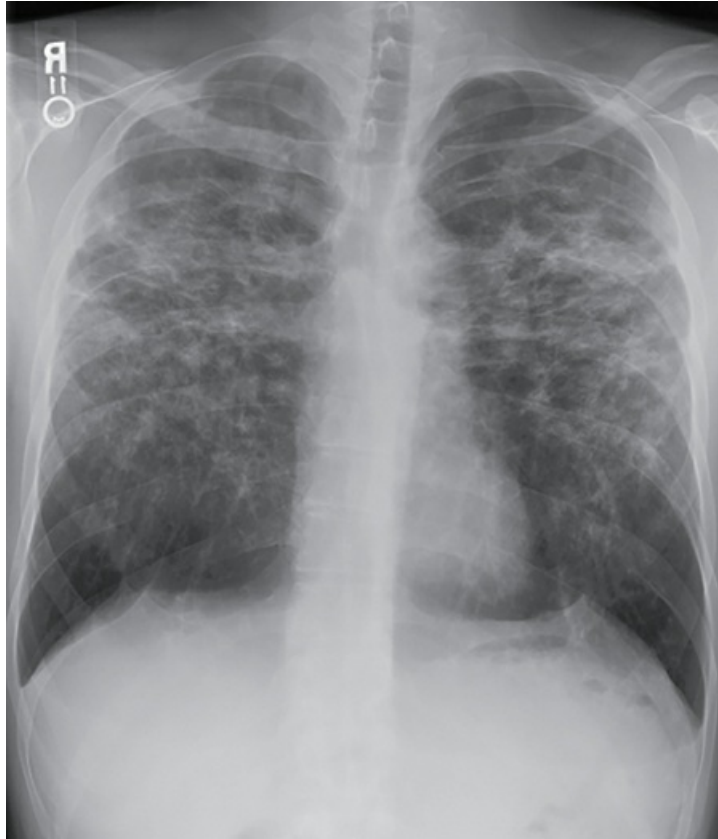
Posteroanterior (PA) chest radiograph of stage III sarcoidosis. There are bilateral interstitial infiltrates, most prominent in the upper lung zones. There is no apparent hilar or mediastinal lymphadenopathy.
